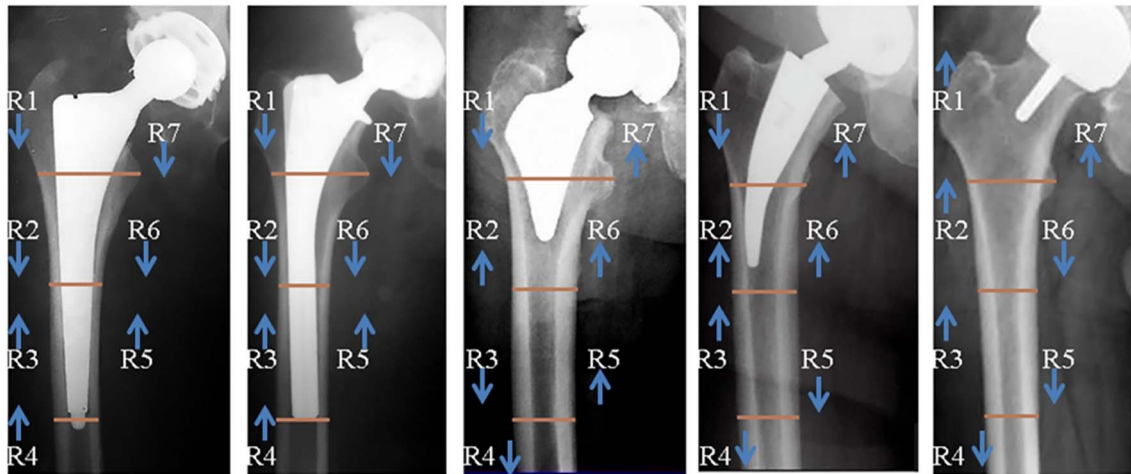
Radiographs of the prosthetic limb two years after implantation: an up arrow shows an increase in bone density, while a down arrow indicates a decrease.
